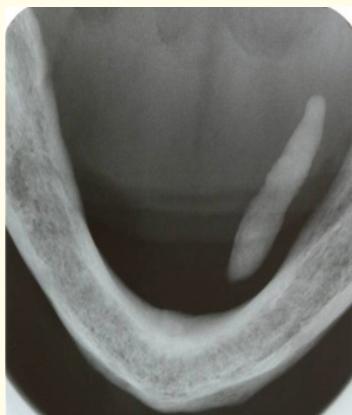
Occlusal x-ray of the floor of the mouth of an edentulous patient where the submandibular calculus is identified.
